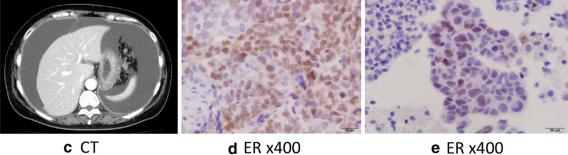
Case 9; 56-year-old woman with ascites. Primary breast cancer exhibited HR (-), HER2 (3+) as shown at a, b. She had adjuvant chemotherapy containing trastuzumab. 3 years later, contrast CT indicated massive ascites (c). Abdominal metastasis was
